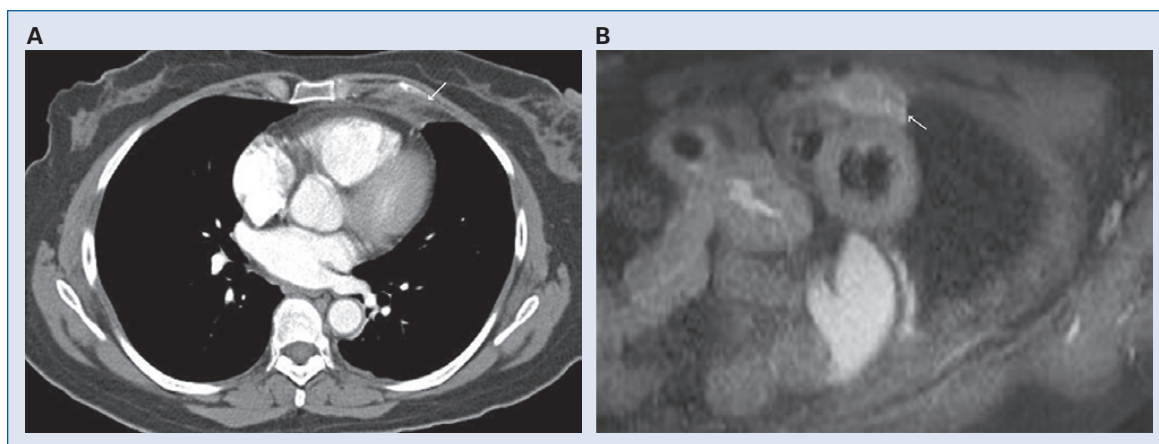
A. Computed tomography scan of the chest showing soft tissue lesion with patchy infiltration without invasion of the overlying chest wall, consistent with epicardial fat necrosis; B. Cardiac magnetic resonance reveals an epicardial lesion anterior to the right ventricle and pulmonary outflow tract demonstrating high signal on the T2 weighted images.
